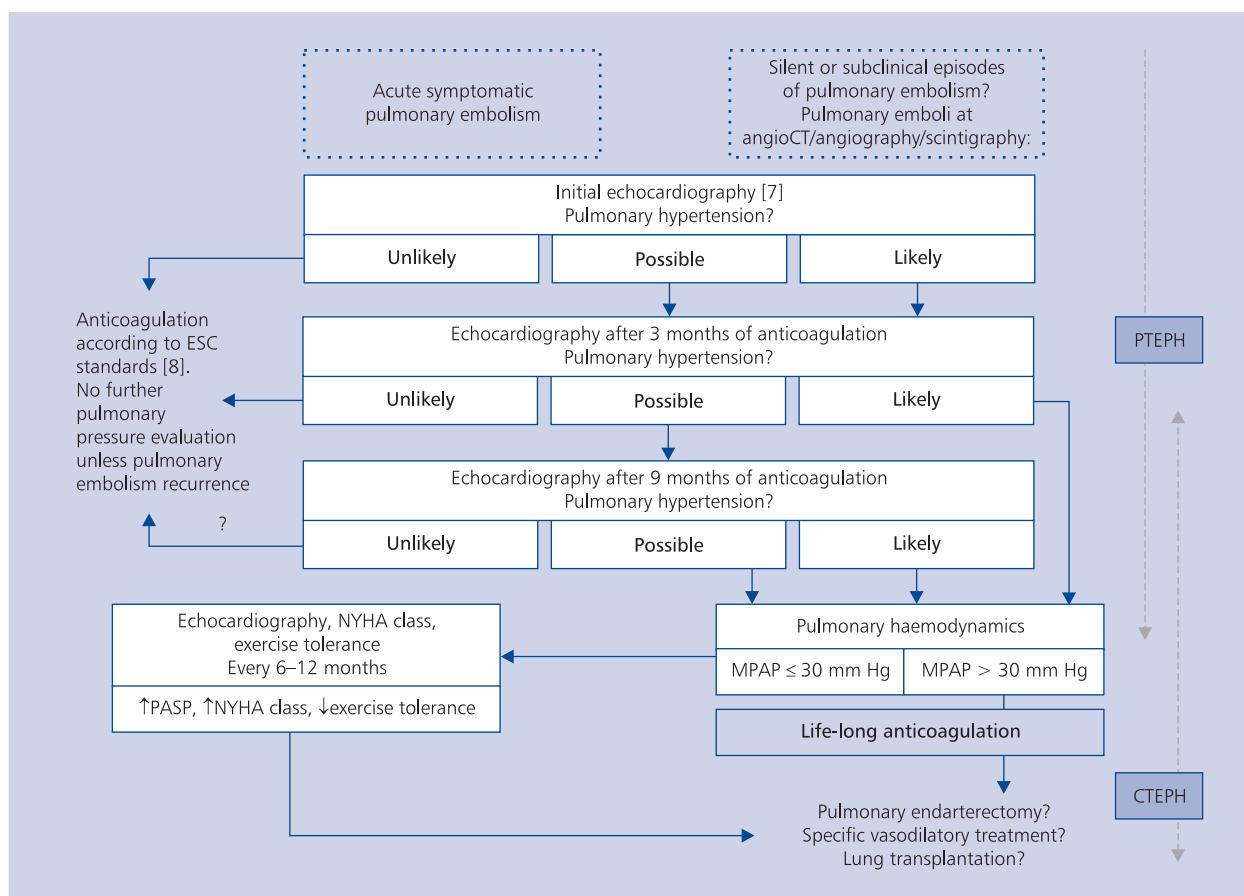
A proposal of an algorithm for the diagnosis and treatment of thromboembolic pulmonary hypertension; CT — computed tomography; CTEPH — chronic thromboembolic pulmonary hypertension; MPAP — mean pulmonary artery pressure; NYHA — The New York Heart Association; PASP — pulmonary artery systolic pressure; PTEPH — persistent thromboembolic pulmonary hypertension
